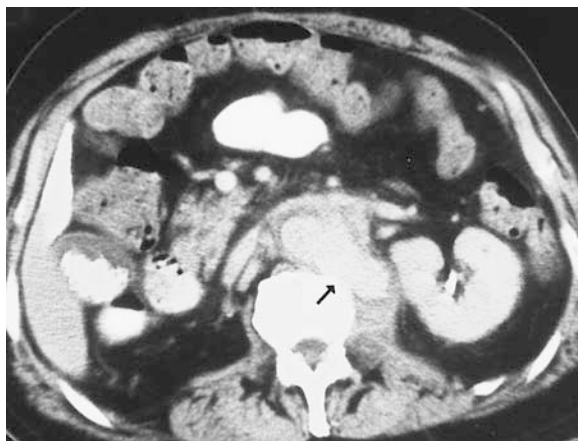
Aortic stump blowout in a patient with back pain and a drop in hematocrit level 6 months after aortic graft removal. CT scan shows a pool of contrast material extending from the aortic stump (arrow), with temporary tamponade of the collection by the left psoas muscle.
